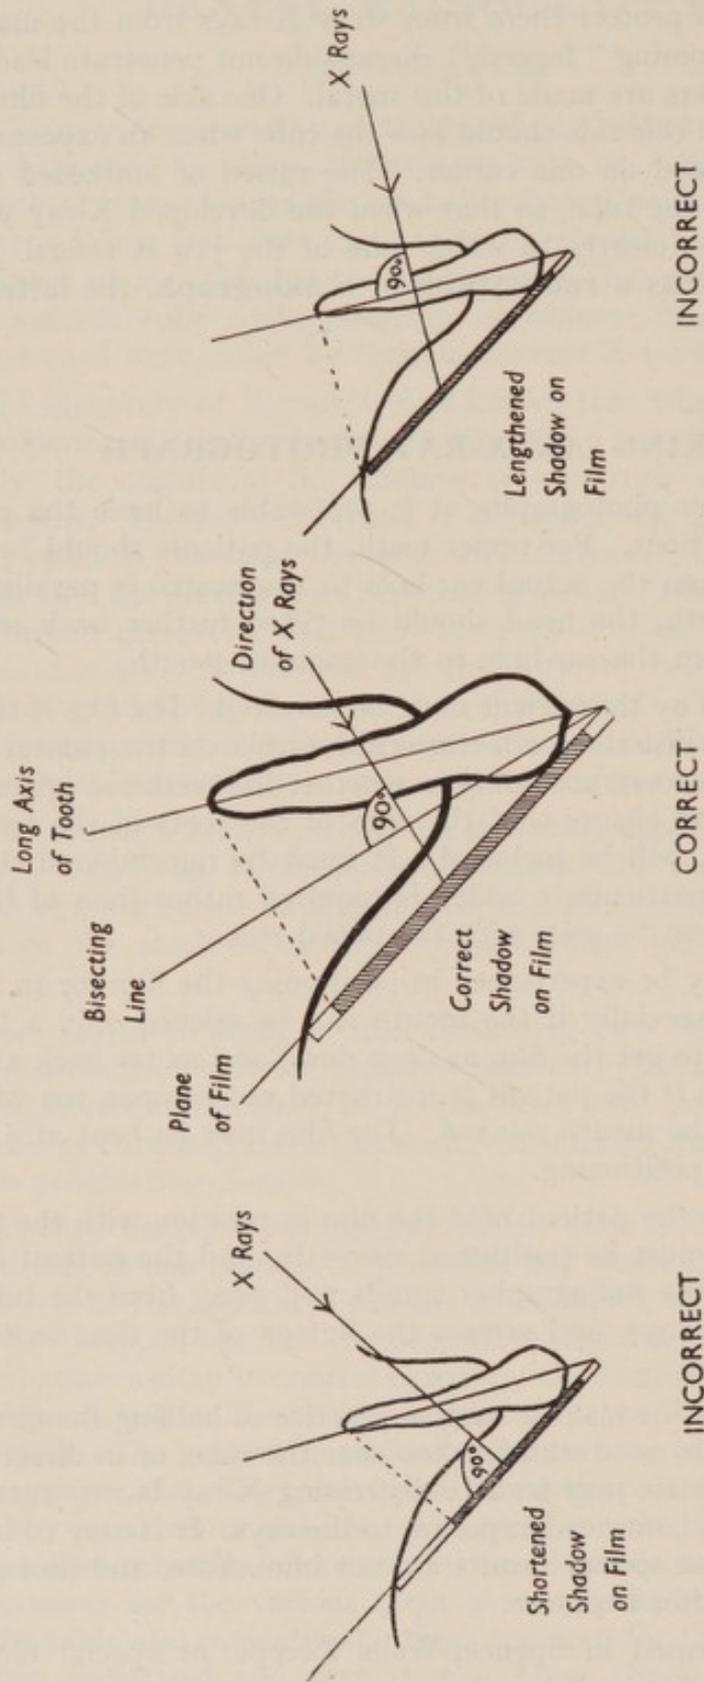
X-Rays—Correct Angle
